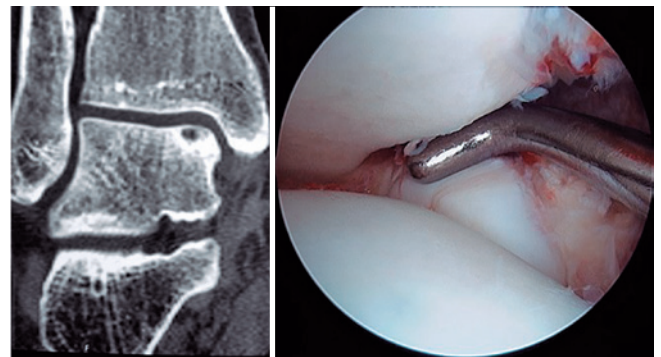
Intact subchondral cyst, computed tomography scan on the left. Arthroscopic image showing no evidence of communication between the cyst and the articular cavity.
